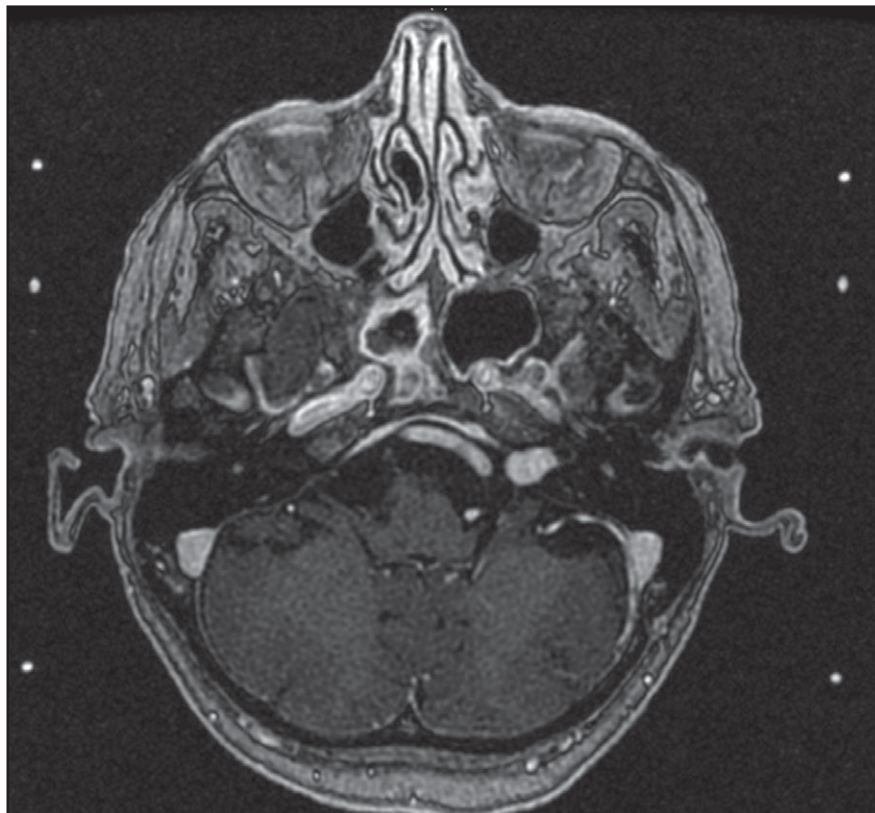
Axial MRI demonstrating an “ice cream cone” lesion in the left cerebellopontine angle and the internal acoustic canal.
